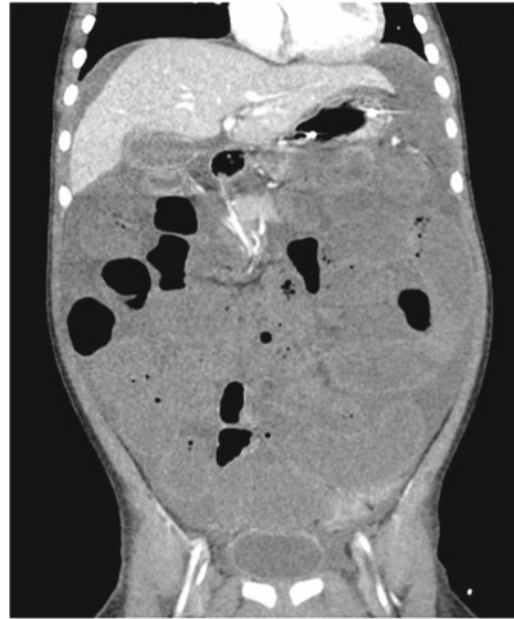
A CT scan demonstrating intestinal volvulus with swirling of the mesenteric vessels, ascites, and pneumatosis intestinalis
